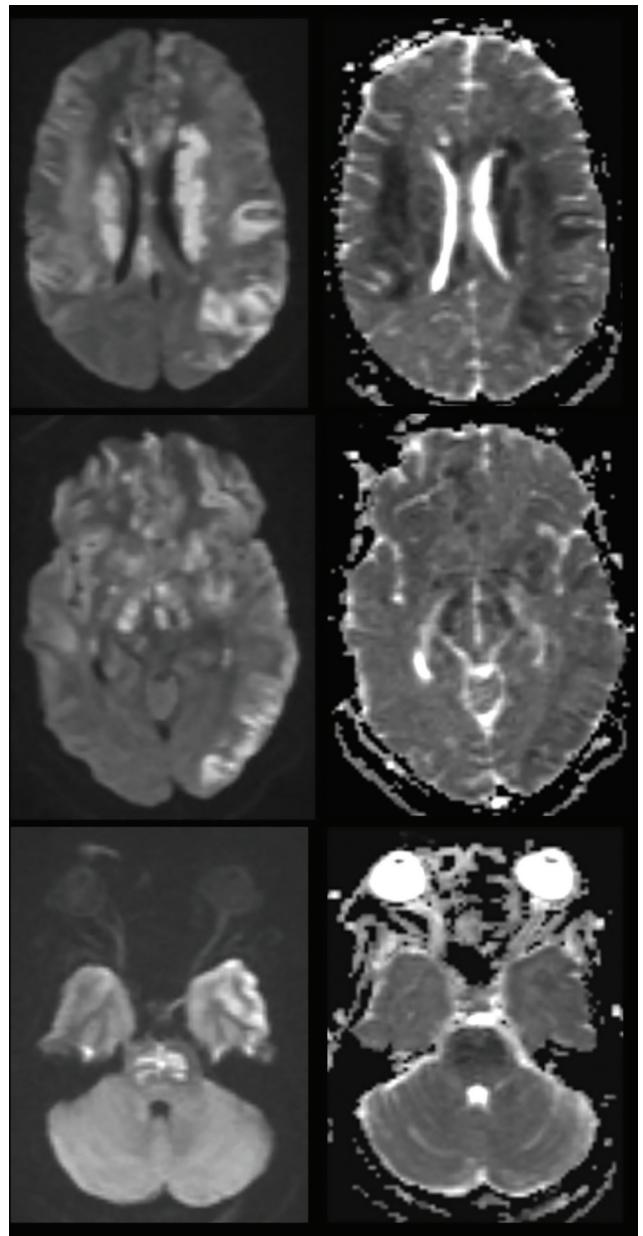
One month after presentation, shortly before the patient died, magnetic resonance imaging showed multifocal areas of patchy parenchymal restricted diffusion that were not associated with localized pathologic enhancement. These features raised suspicion for acute infarction along the genu and body of the corpus callosum, left corona radiata and corpus striatum, juxtacortical left frontal operculum, left temporal stem and anterior temporal white matter, right anterior temporal white matter, anterior commissure and fornix columns, right posterior limb internal capsule, right hippocampal body, left cingulate gyrus, and left parietal convexity.
